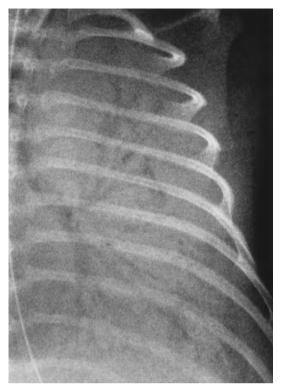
Air bronchogram. The air-filled bronchial tree stands out against the background of consolidated lung in fatal staphylococcal pneumonia in a 1-month-old infant. Rapid evolution of complete pulmonary consolidation within a few hours caused the entire bronchial tree to be visible on this plain radiograph of the left hemithorax.
